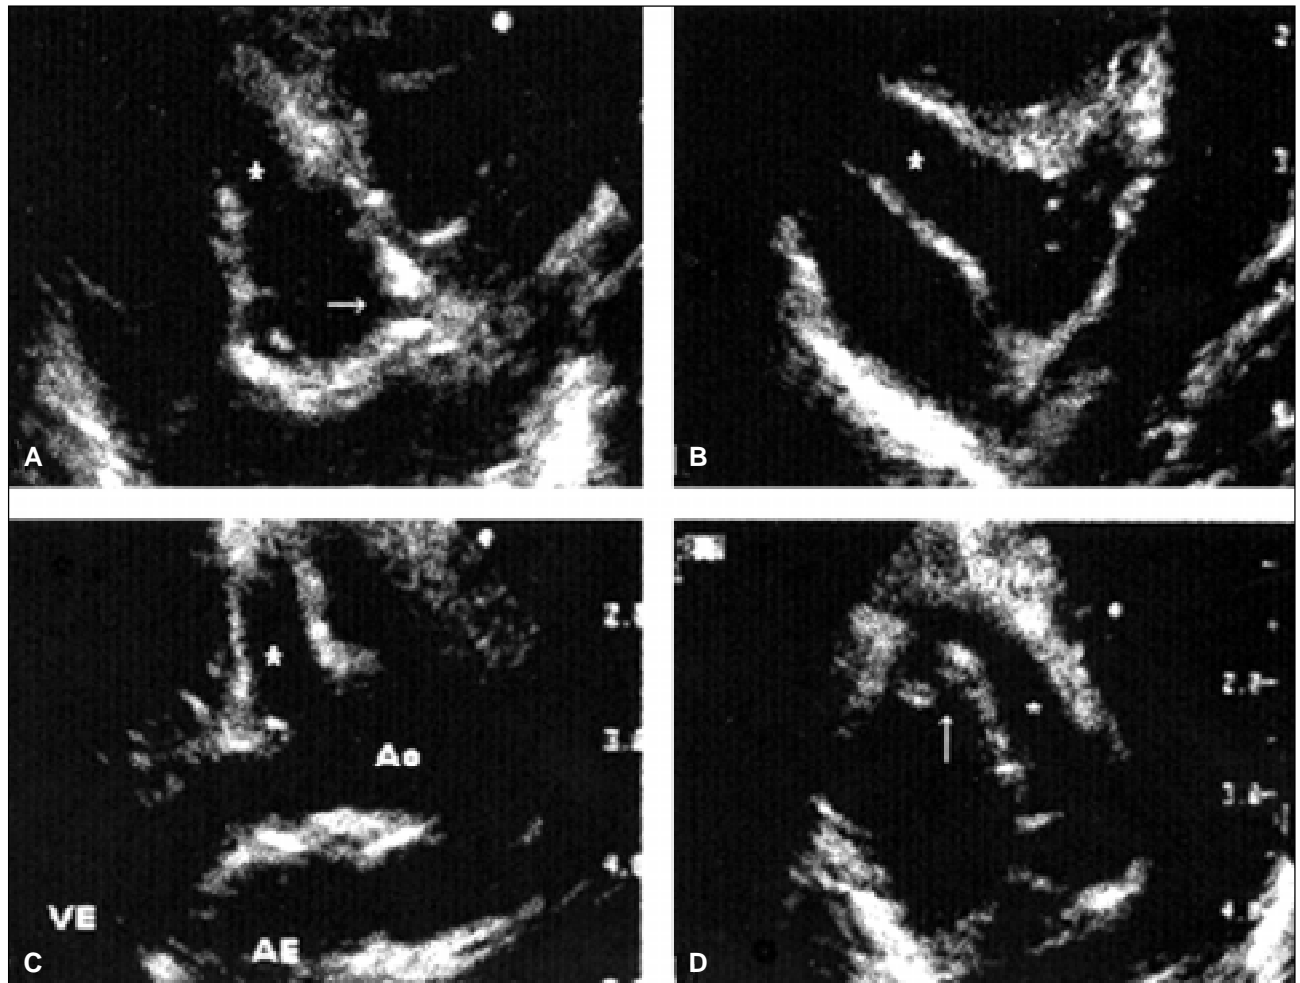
Echocardiographic data: A) cross parasternal view of the aortic root showing the origin of the right (*) and left (arrow) coronary arteries; B) right coronary artery (*) is seen in the atrioventricular sulcus; C) longitudinal parasternal view showing the trajectory of the right coronary artery (*); D) the arrow shows the point of drainage of the fistulous trajectory. ACD- right coronary artery.
